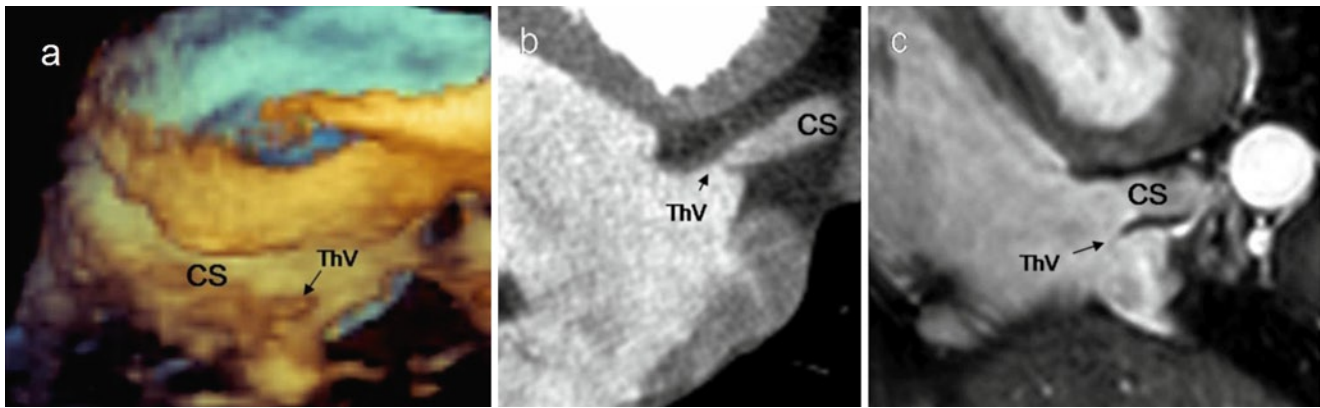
(a) RT 3D TEE image, (b) CT, and (c) MRI slices showing the coronary sinus (CS) and the Thebesian valve (ThV)
